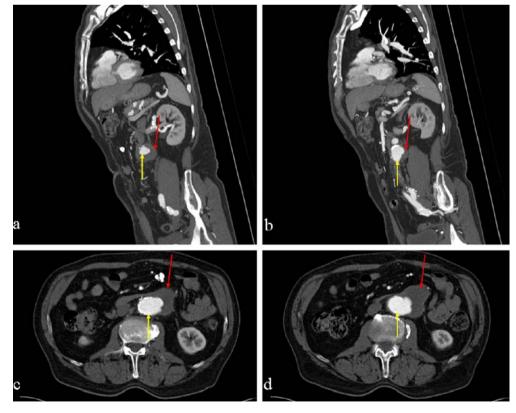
Same patient as Fig. 2. CTA in sagittal (a, b) and axial (c, d) planes demonstrating a covered abdominal aortic rupture (*yellow arrows*) with periaortic hematoma (*red arrows*). No contrast extravasation could be detected
